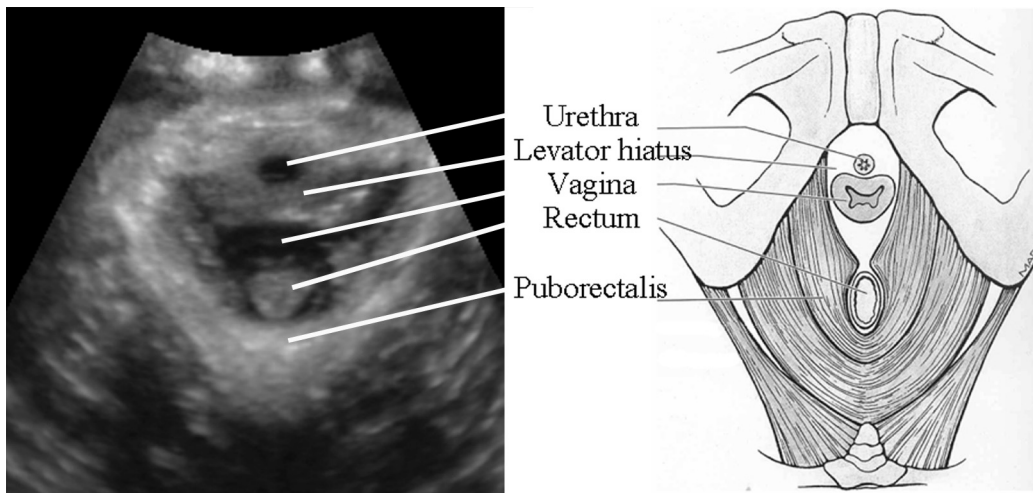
Normal 3D anatomy of the pelvic floor in the axial plane as seen on transperineal ultrasound.
